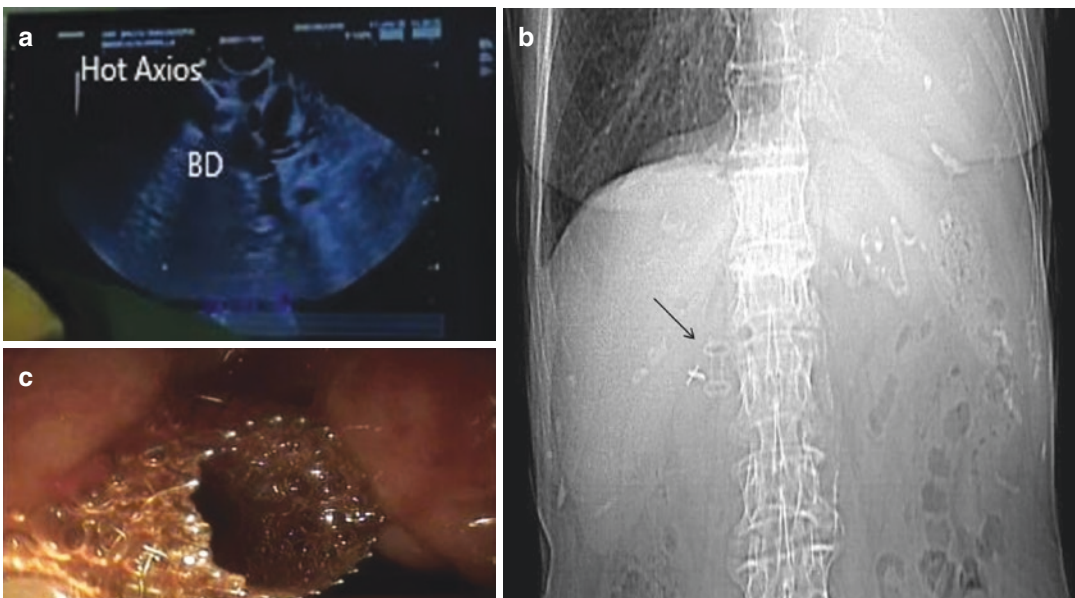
Extrahepatic approach (a) Endoscopic ultrasonography-guided choledochoduodenostomy using a LAMS (Hot AXIOS device, Boston Scientific) (b) CT-scan view (c) Endoscopic view. *BD=bile duct*
